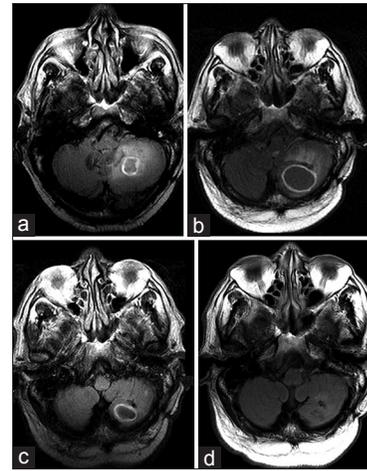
Evolution of TB Cerebellar Abscess on T2 FLAIR Imaging. (a) Contrast enhanced axial T2 FLAIR at 4-month follow up shows significant perilesional edema. (b) Contrast enhanced axial T2 FLAIR at 9-month follow up showed residual perilesional edema, which had decreased since prior study, even though the cavitation size had increased. (c) Contrast enhanced axial T2 FLAIR at 11-month follow up and 14 month follow up (d) showed minimal to no perilesional edema
